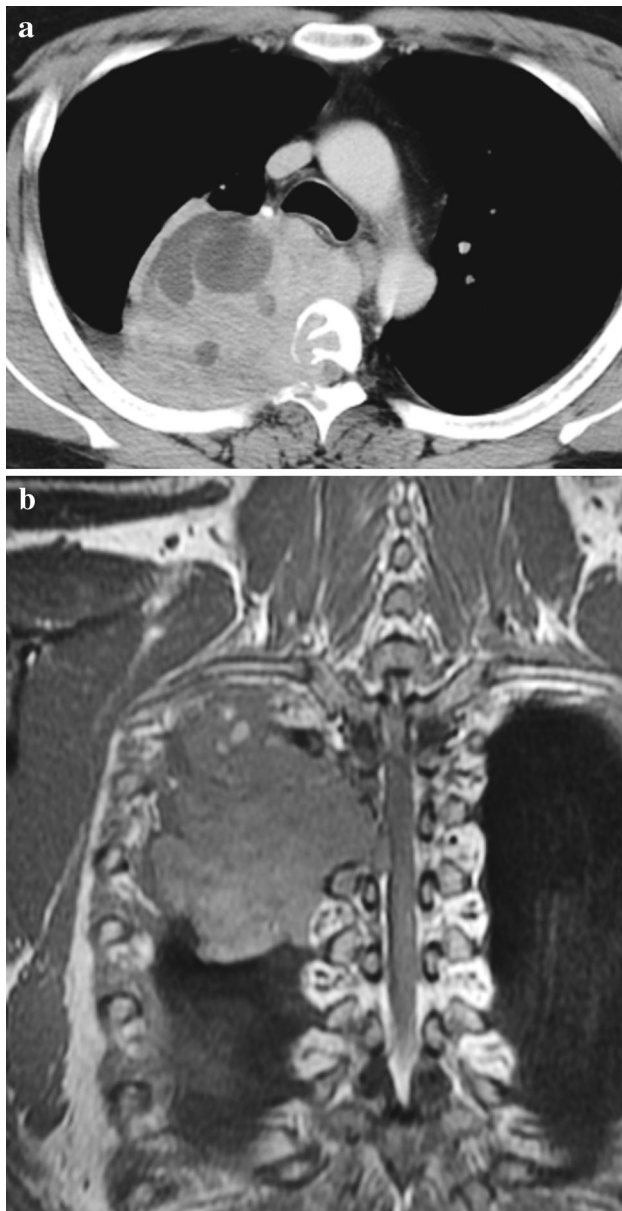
a CT scan showing a heterogeneous structure in the fourth rib invading the third and fourth thoracic vertebrae. b Axial MRI demonstrating extension of the mass into the spinal canal through the intervertebral foramina
